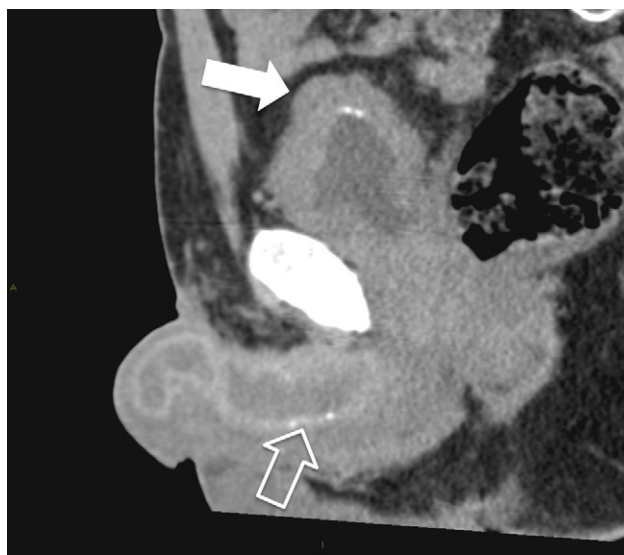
Tuberculosis. Sagittal view CT scan without injection of contrast medium: calcifications of the bladder (solid arrow) and the corpus cavernosum penis (arrow outline).
